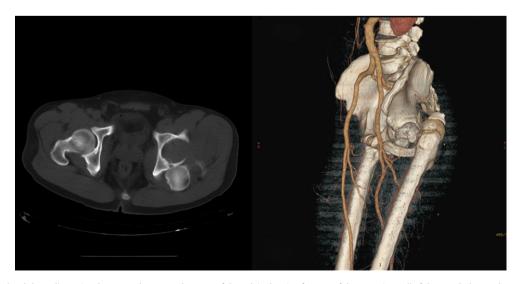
Two-dimensional and three-dimensional computed tomography scans of the pelvis showing fracture of the posterior wall of the acetabulum and posterior dislocation of the femoral head.
